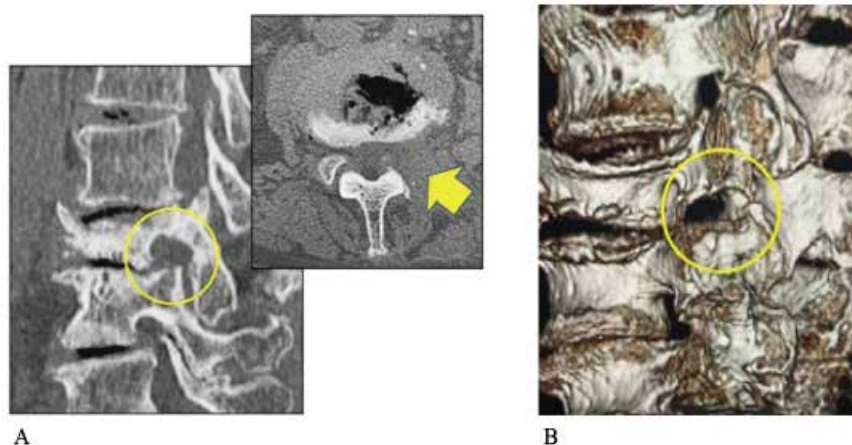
Postoperative CT images. A : Multi-planar reconstructed sagittal and axial CT images showing adequate bony decompression after resection of the left SAP of L4 (yellow circle and arrow). B : Three-dimensional reconstructed CT image showing enlargement of the intervertebral foramen on the left at L3-L4.
